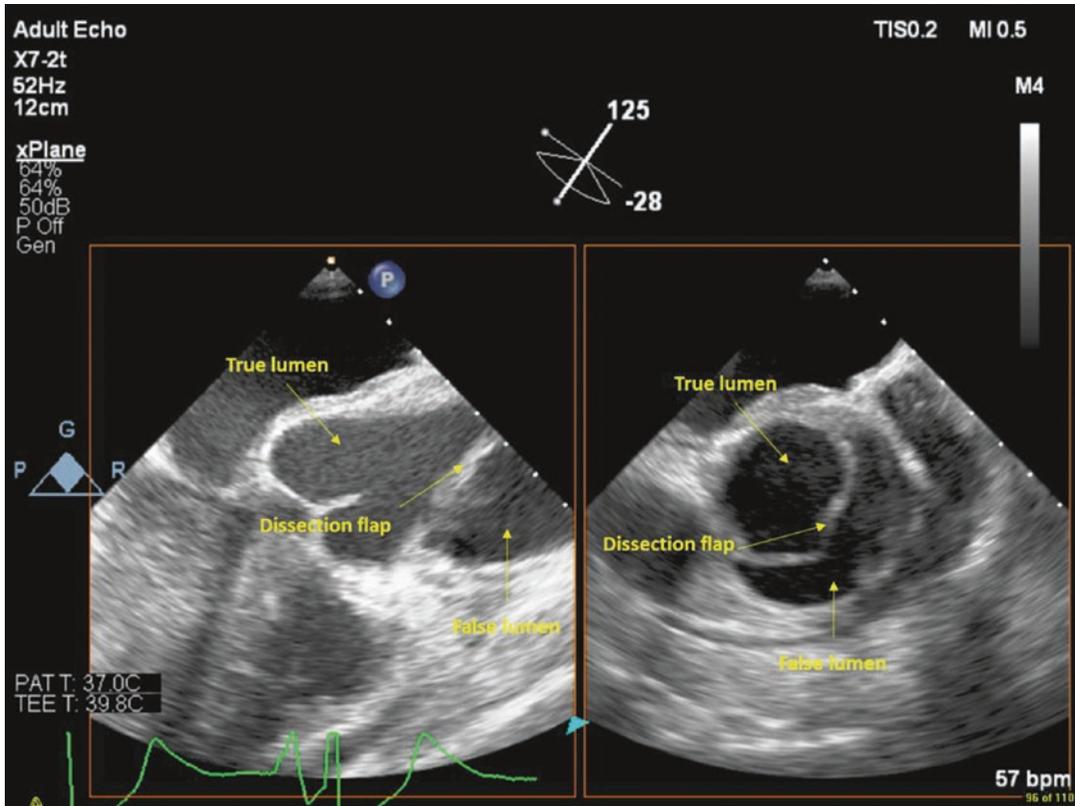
Echocardiogram of an aortic dissection. Arrows marking the dissection flap and true and false lumen
